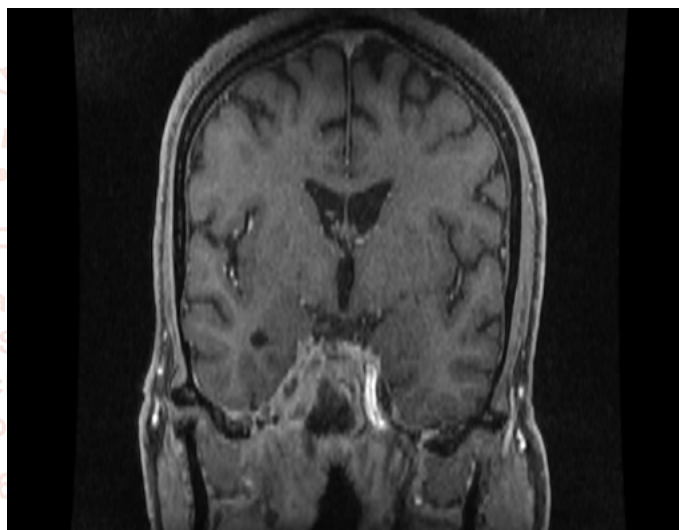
Contrast T1W MRI showing the right Cavernous sinus is widened and enhancement of soft tissue component.
